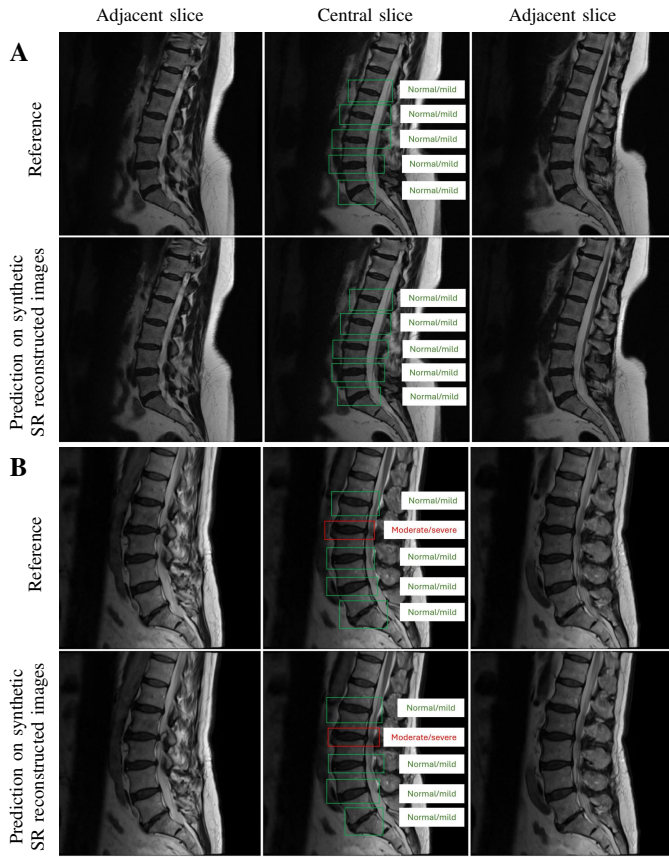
IVDD detection results of synthetic ULF MRI SR reconstructed data from (A) one healthy subject and (B) one subject with disc degeneration in the per-lesion level. The model utilizes multi-slice information to yield predictions for the central slice. For both two subjects, the model could correctly predict the boxes and box labels for the disc of interest.
